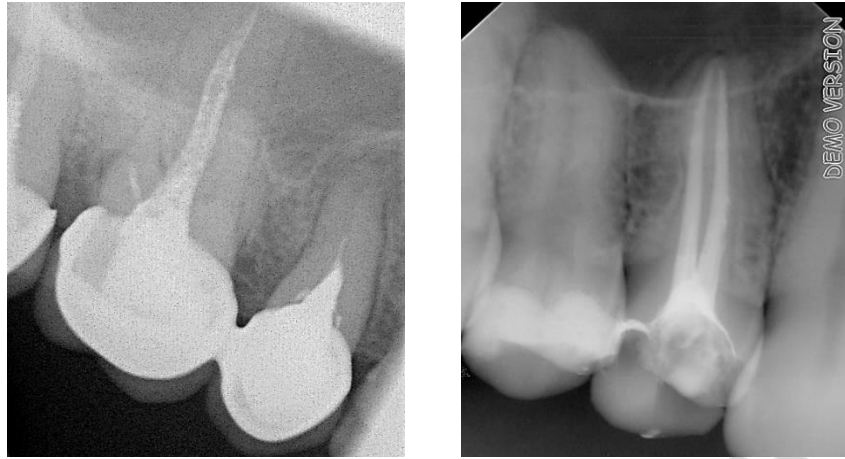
Doubtful (on the left) and suitable (on the right) X-ray criteria of endodontic treatment
